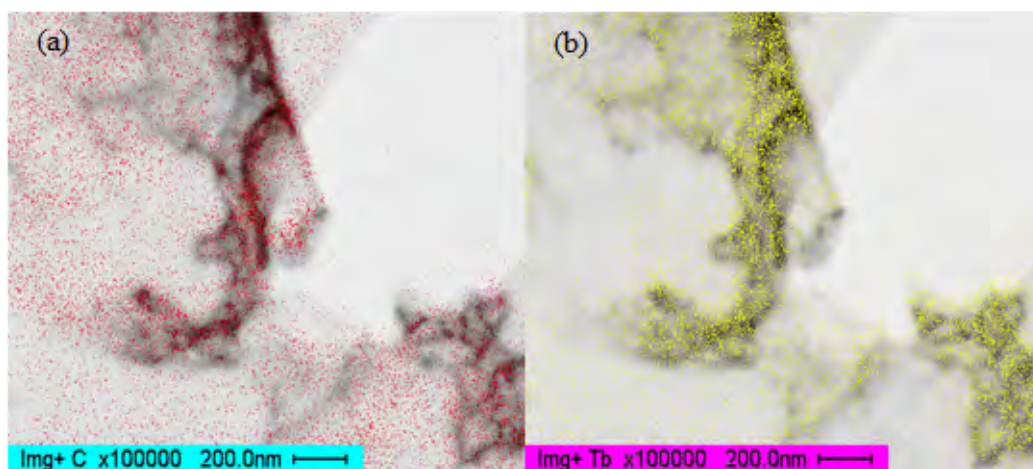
The carbon/oxygen (a) and terbium (b) X-ray map of terbium graphene oxide.
